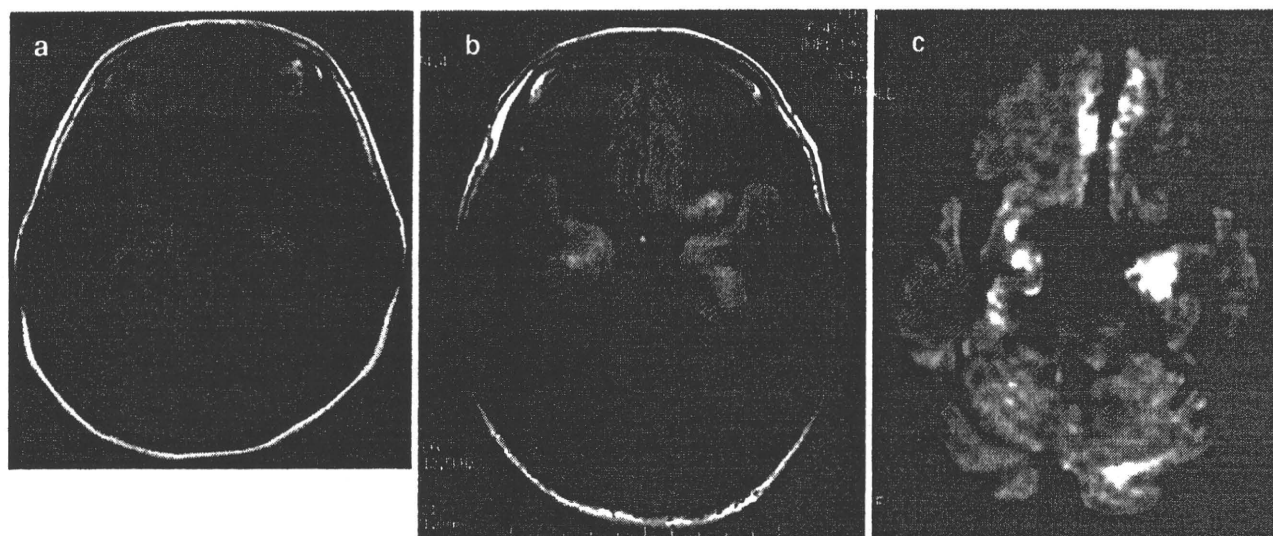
a Fast fluid-attenuated inversion-recovery (FLAIR) MRI of a 42-year-old female patient revealing a high-signal-intensity lesion in both temporal lobes. b FLAIR MRI of a 43-year-old female patient
